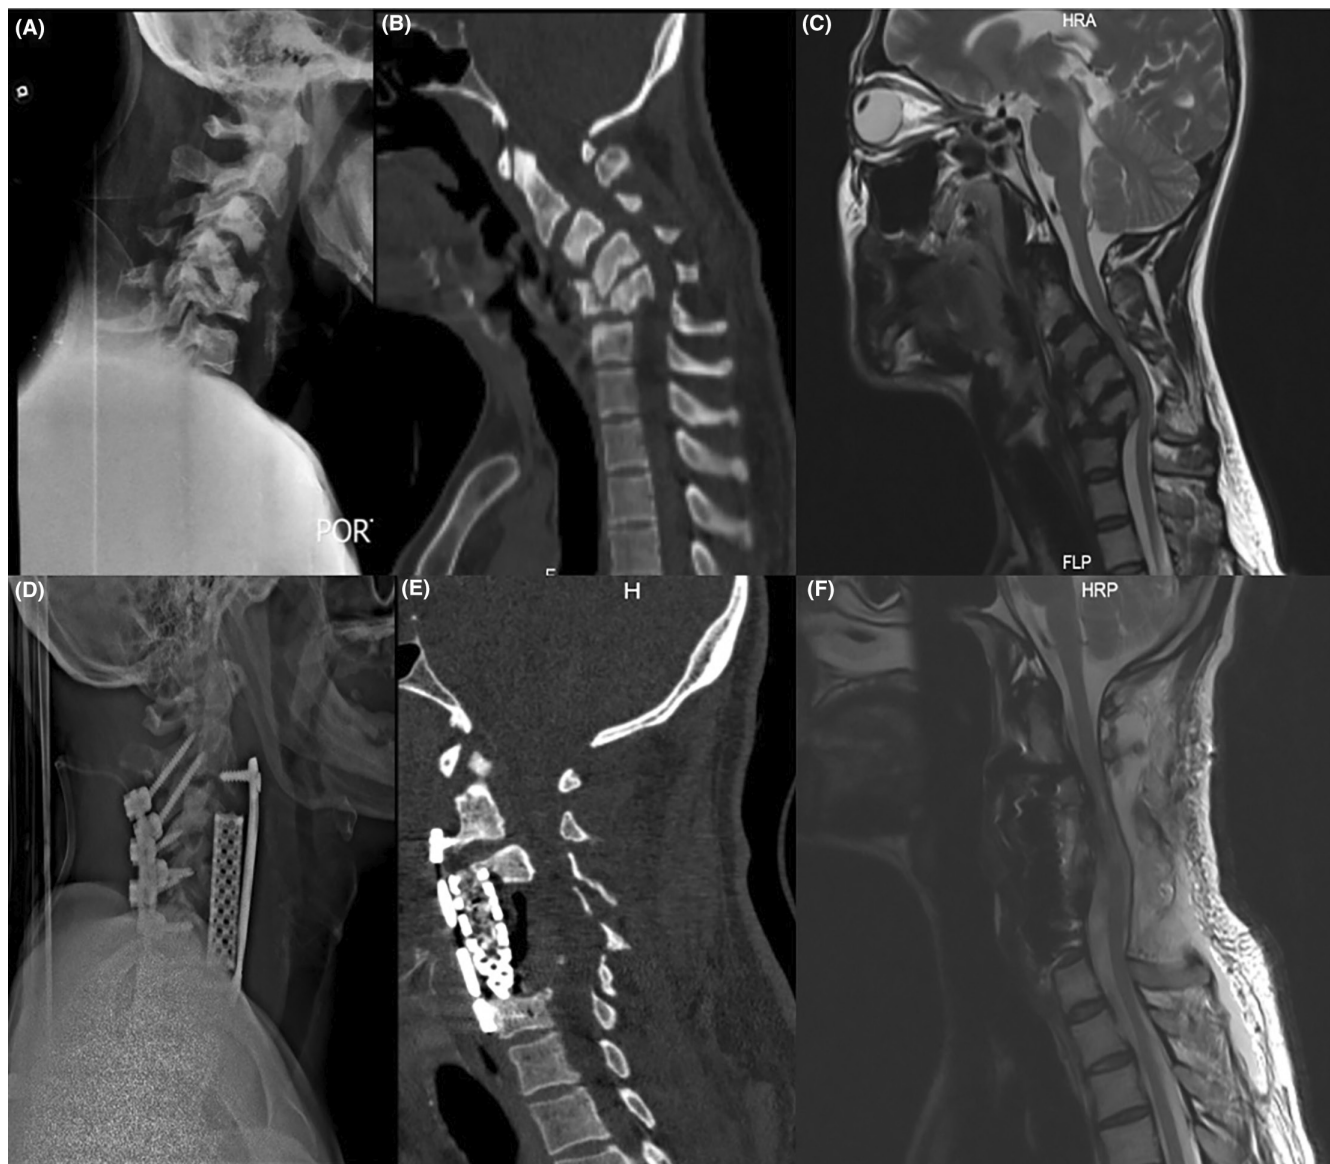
Preoperative (A) neck x-ray, (B) CT scan, and (C) MRI (T2-weighted sagittal view) show cervical kyphosis leading to severe spinal cord compression due to the previous trauma. Postoperative counterpart (D) x-ray, (E) CT scan, and (F) MRI (T2-weighted sagittal view) display spinal cord decompression and maximal safe correction via anteroposterior approach (AP approach).
